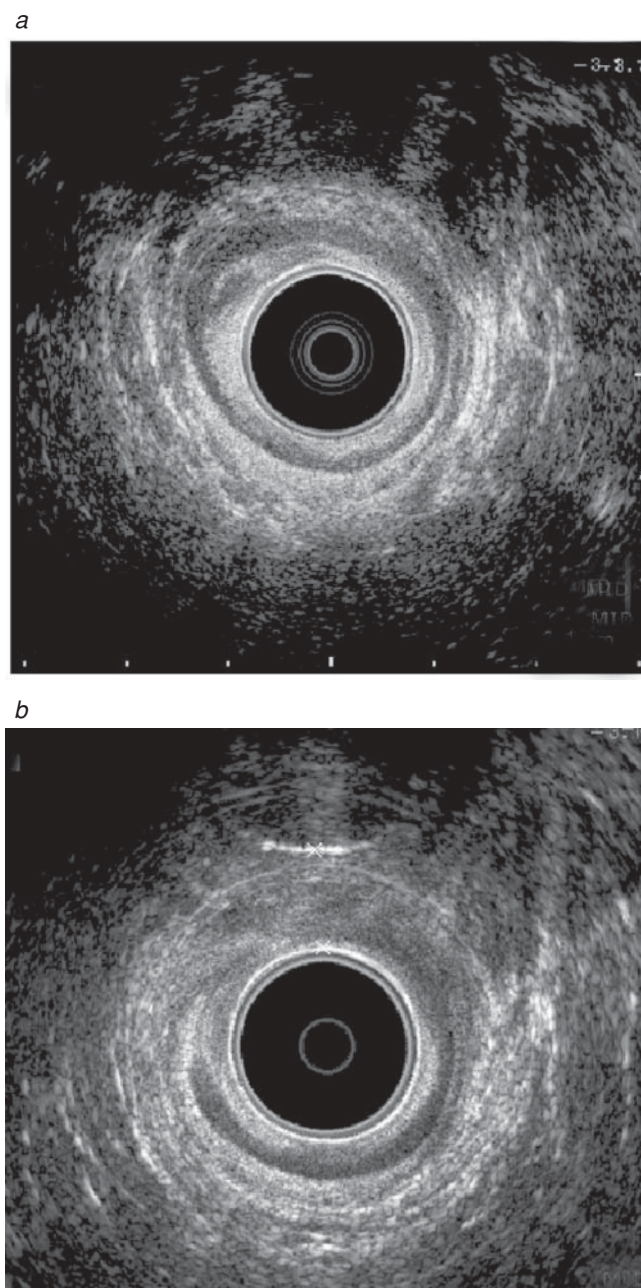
Endoanal ultrasonograms show (a) a normal anal sphincter and (b) a sphincter defect.
